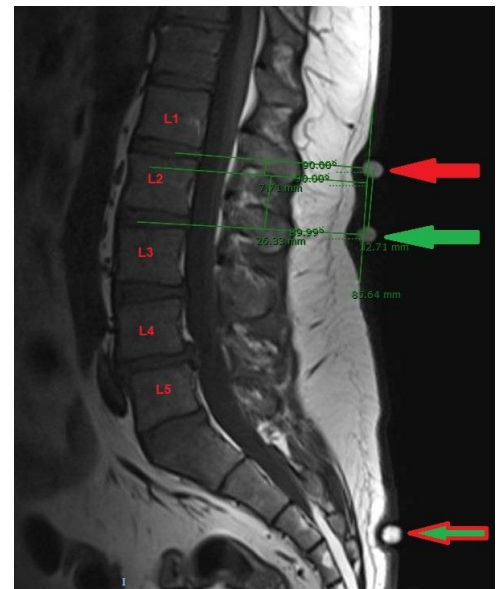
Localization of the superior marking on MRI for MST (green arrow) and new test (red arrow). In this participant, the inferior marking (green/red arrow) was the same
